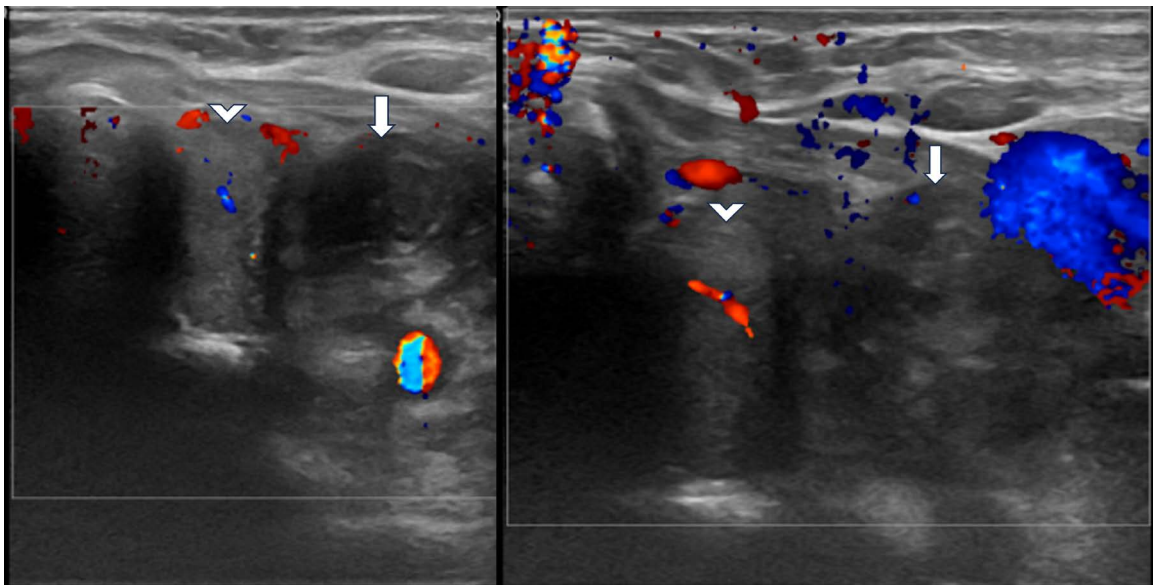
Transverse Color Doppler images at the level of the thyroid gland demonstrate a heterogenous, relatively avascular/necrotic mass (arrow) adjacent to the inferior pole of the left lobe of the thyroid gland (arrowhead).
